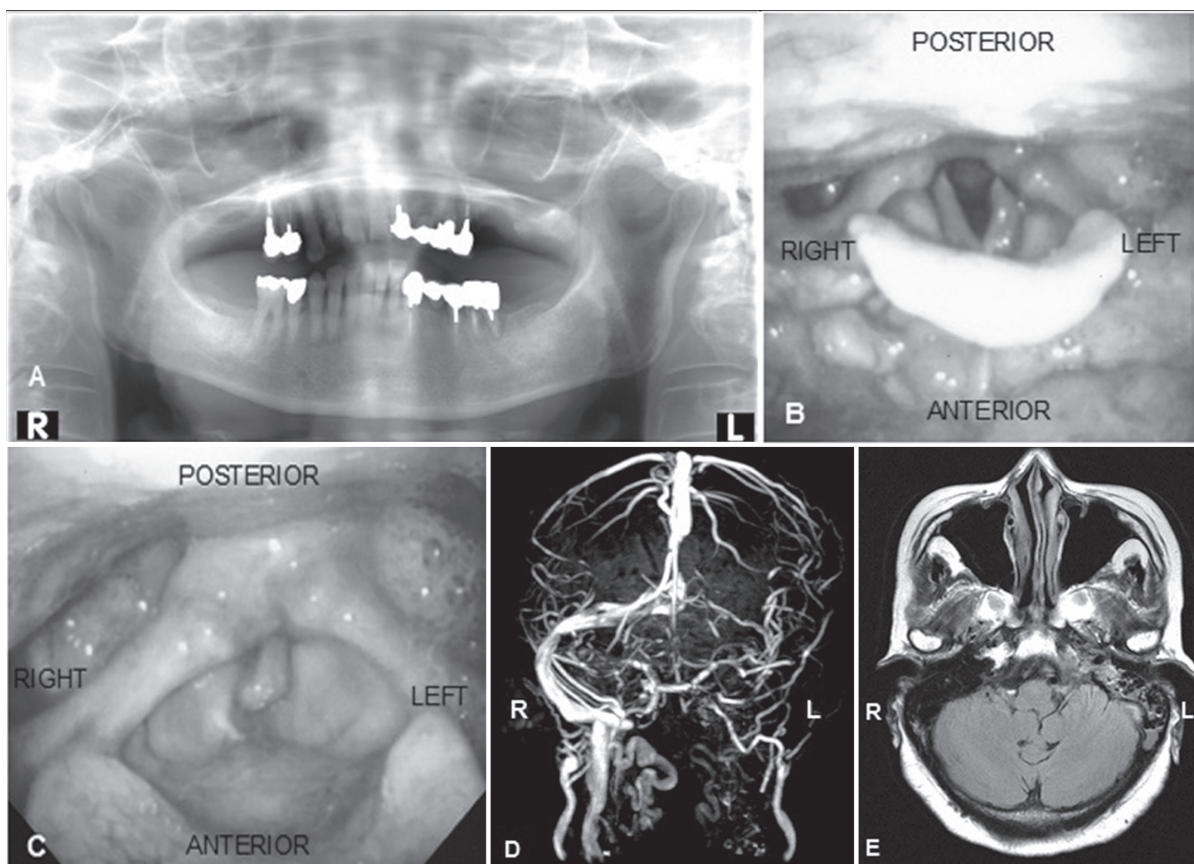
A: Dental pantomography on day 39 showing notable bone loss and teeth defects in the moderate periodontitis. B, C: Vocal cords abducted (B) and vocal cords adducted (C). Flexible fiberoptic laryngoscopy imaging on day 0 showing incomplete motion of the left vocal cord and pooling of saliva in the left piriform fossa. D: Magnetic resonance venography of the head on day 22 showing a diminished perfusion of the left internal jugular vein, the left sigmoid sinus, and the left transverse sinus as a sign of thrombosis. E: Transversal fluid attenuation inversion recovery (FLAIR) image on day 22 revealing fluid collection within the left mastoid air cells and the middle ear.
